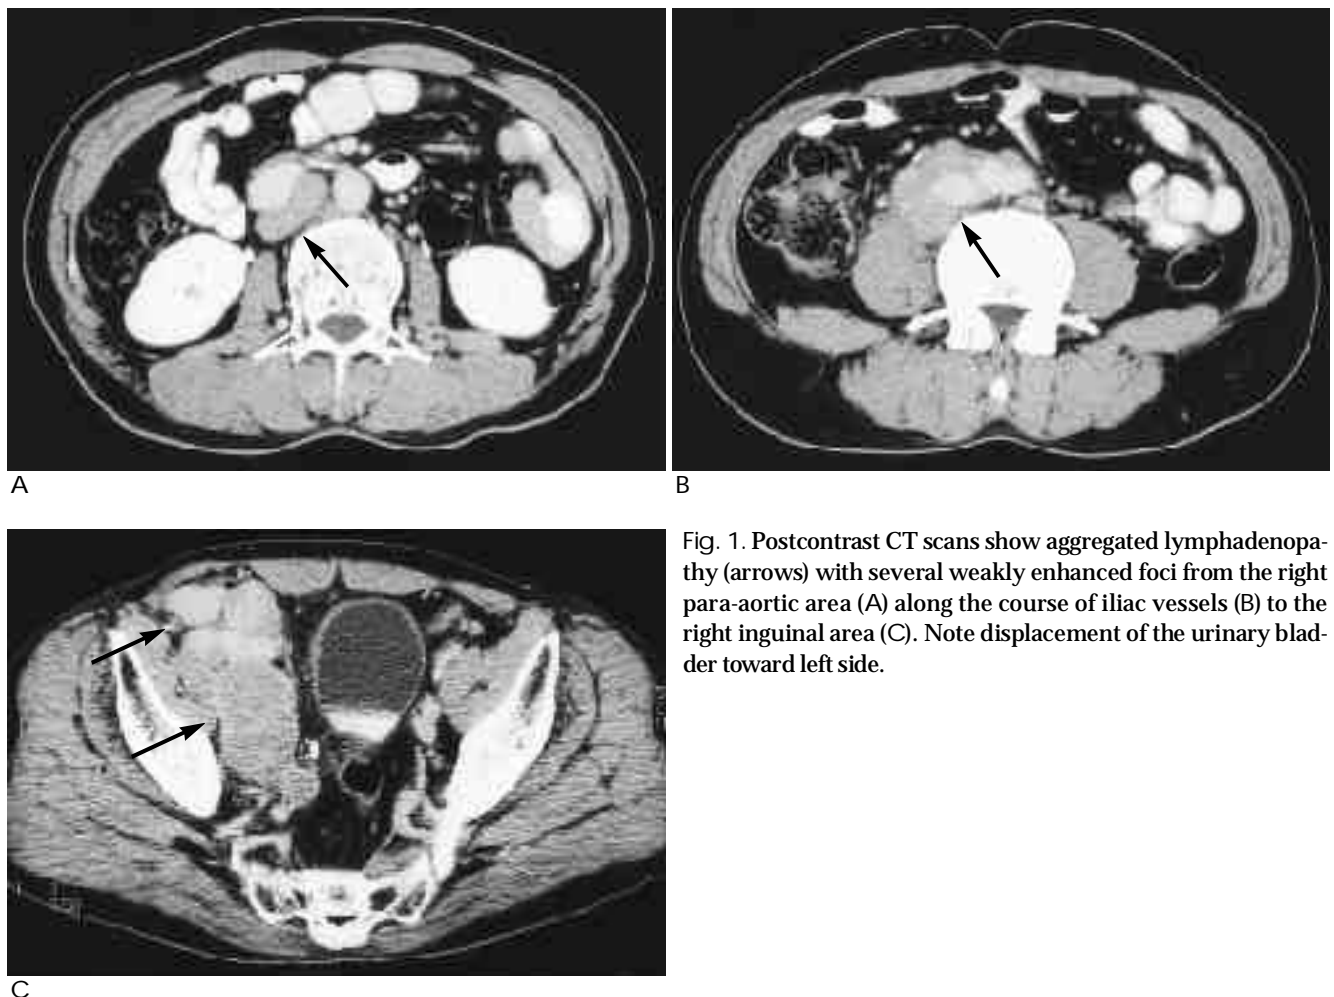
Postcontrast CT scans show aggregated lymphadenopathy (arrows) with several weakly enhanced foci from the right para-aortic area (A) along the course of iliac vessels (B) to the right inguinal area (C). Note displacement of the urinary bladder toward left side.
